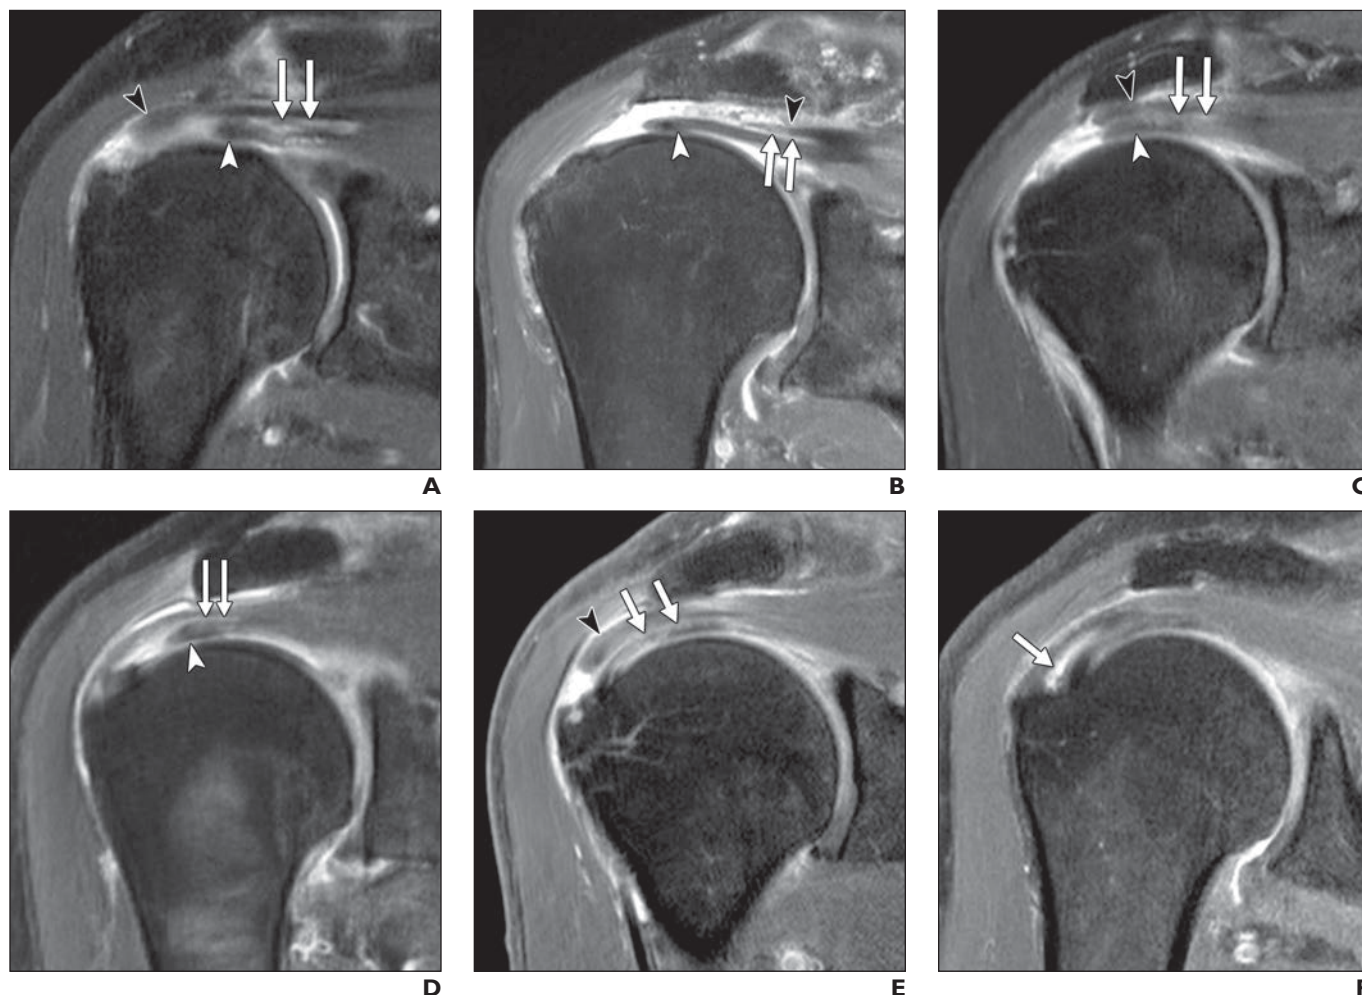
Fat-suppressed T1-weighted coronal images of indirect MR arthrography of shoulders show six types of delaminated tears at supraspinatus-infraspinatus tendons. A–F, Serial MR images show articular-delaminated full-thickness tear in 59-year-old man (type 1a) (A), bursal-delaminated full-thickness tear in 58-year-old man (type 1b) (B), intratendinous-delaminated full-thickness tear in 64-year-old man (type 1c) (C), articular-delaminated partial-thickness tear in 58-year-old man (type 2a) (D), bursal-delaminated partial-thickness tear in 69-year-old man (type 2b) (E), and intratendinous-delaminated partial-thickness tear in 51-year-old man (type 2c) (F). Intratendinous horizontal clefts in each of delaminated tears are shown as high signal intensity on images (arrows). White arrowhead indicates articular layer, and black arrowhead indicates bursal layer.
